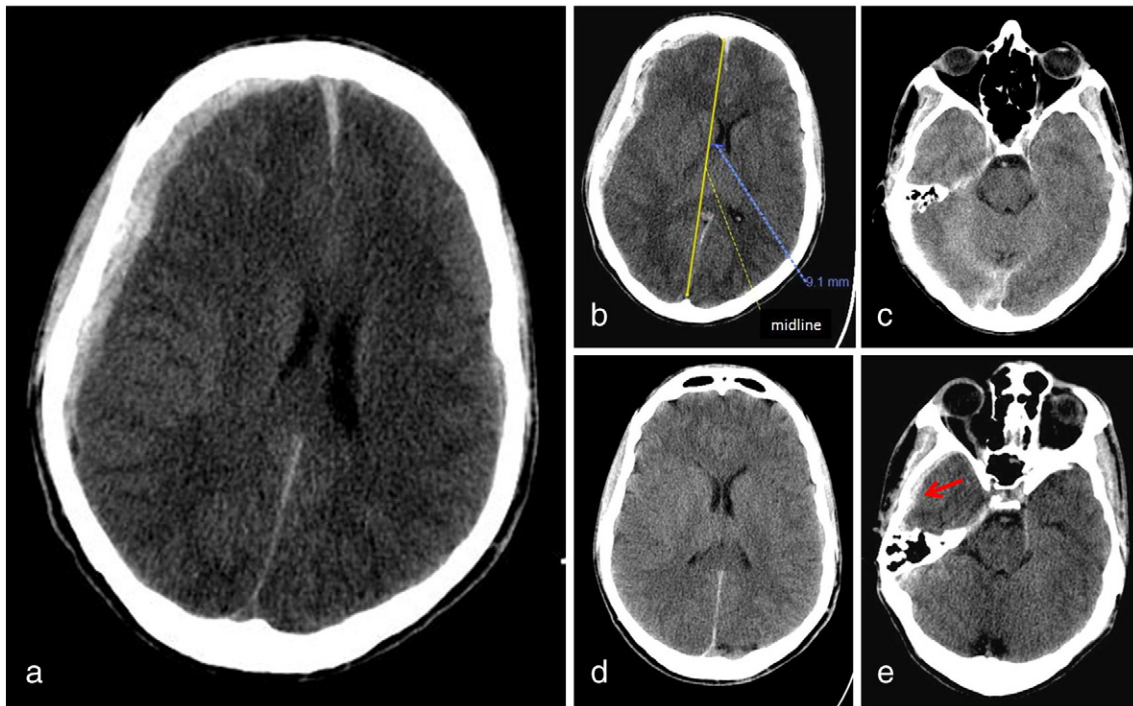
a to c, CT images on admission. a and b, Axial CT section at convexity level. Acute subdural hemorrhage in the right hemisphere and a midline shift is apparent. c, Simultaneous axial CT section at tentorial level. d and e, Computed tomographic images at 8 hours. Axial sections taken from the same level used in Fig. 1. d, Subdural blood is resolved at convexity level. e, Vague areas of hyperdensity on the cortical surface of the right inferior temporal gyrus at tentorial level, on the left at tentorial level, and on the tentorial free margin facing the pons.
